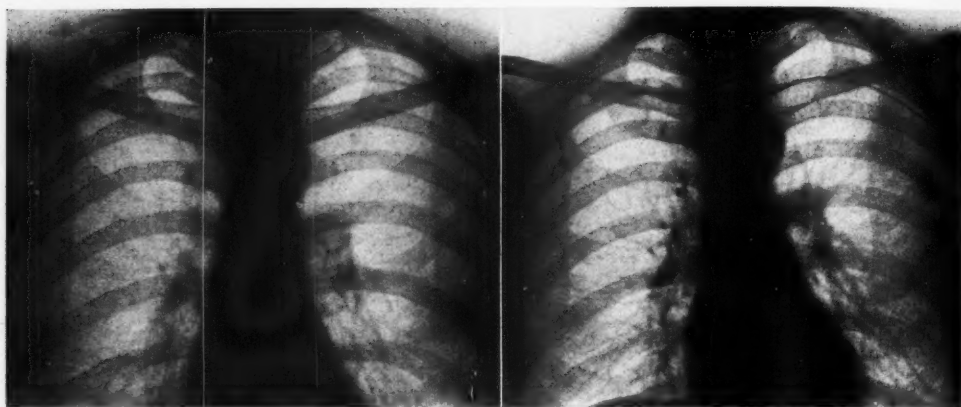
A and 2-B. Roentgenograms (*A* before, *B* after) made after the injection with two catheters.
